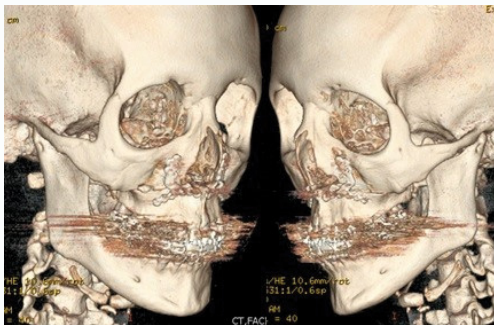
Three dimension reconstituted CT scan showing immediate post-operative imaging with bilateral Lindorf style advancement plates fixing the maxilla to the midface.
